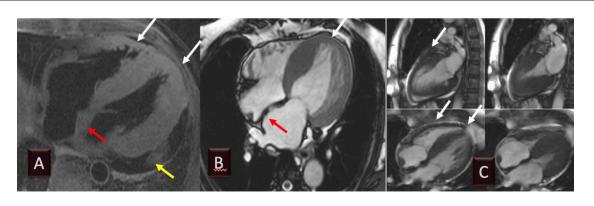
Example of cardiovascular magnetic resonance imaging of transthyretin amyloidosis, showing pericardial effusion (A, yellow arrow and C), increased atrial dimensions (A and B), and increased interatrial septum (A and B, red arrows) and ventricular wall thickness (A to C, white arrows). Diastolic function is reduced, but contractility may be preserved until the later stages of the disease. (Image from the authors' personal archive).
